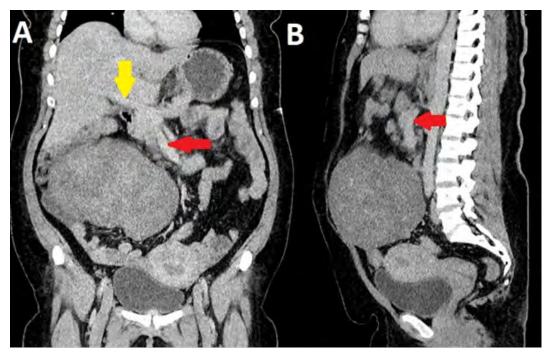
In the diagnosis, coronal (A) and sagittal (B) contrast-enhanced computed tomography images show a large intraabdominal mass and contrasted portal vein (yellow arrow) and superior mesenteric vein (red arrow).
